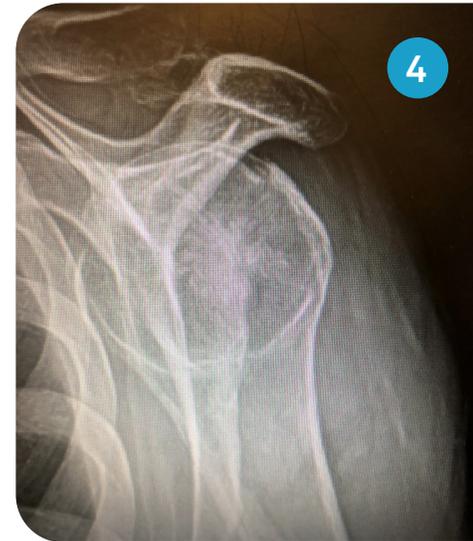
Post-op radiograph demonstrating spread of Tactoset adjacent to anchor tunnel.
